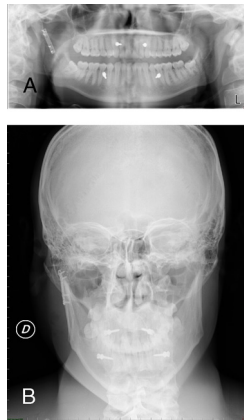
A and B, Postoperative conventional radiography demonstrating the successful reduction.
